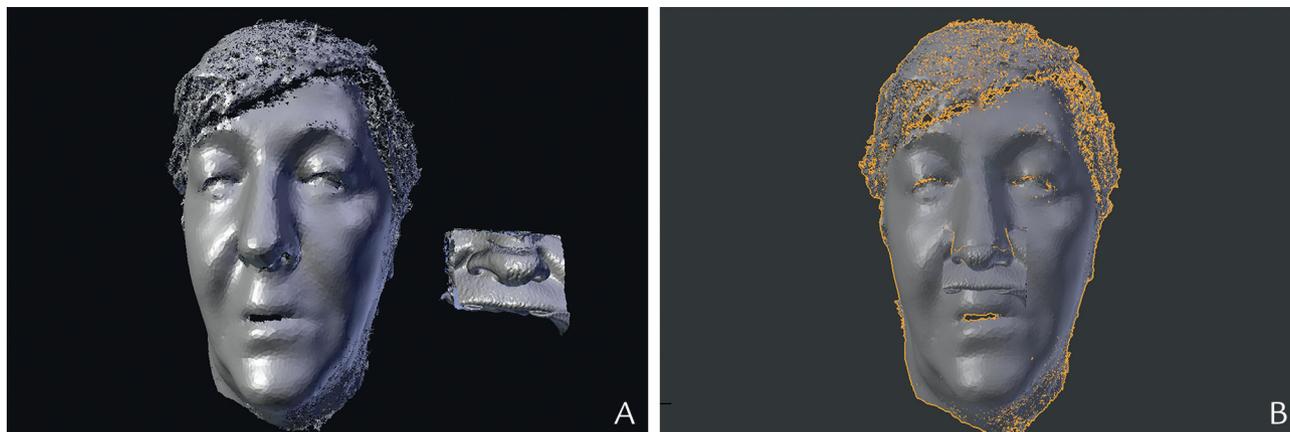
A, STL file of extraoral digitalization of patient's face and STL file obtained from CBCT of patient imported into 3D CAD software. B, Best fit alignment obtained using ICP algorithm of software. CAD, computer-aided design; CBCT, cone beam computed tomography; ICP, iterative closest point; STL, standard tessellation language.
